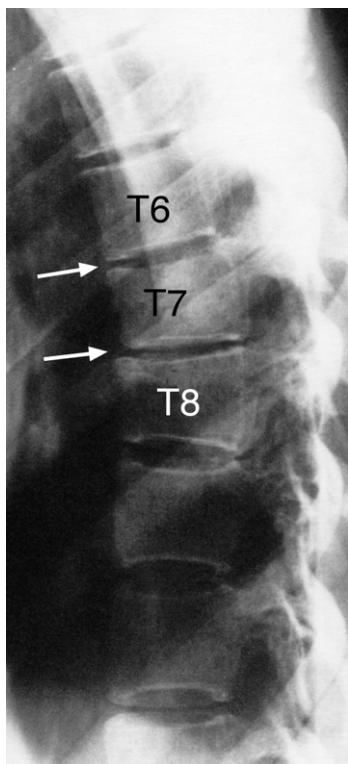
Thoracic spine lateral plain X-ray image showing anterior wedging of the bodies of T7 and T8 indicating compression fractures of these vertebral bodies. Also note the slight narrowing of the T6–7 and T7–8 disc spaces (white arrows).
